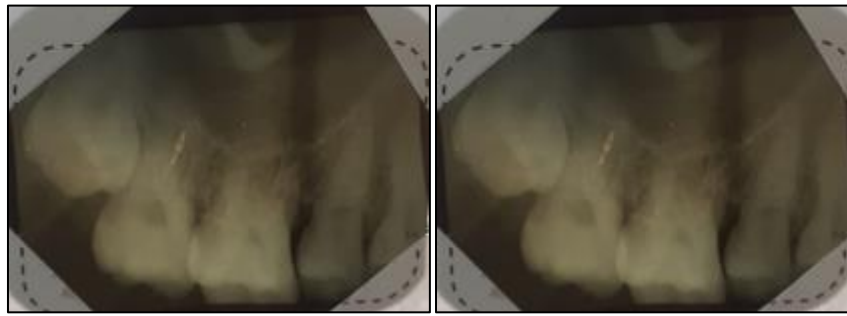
Radiographic examination showed bone resorption on proximal 11-17
